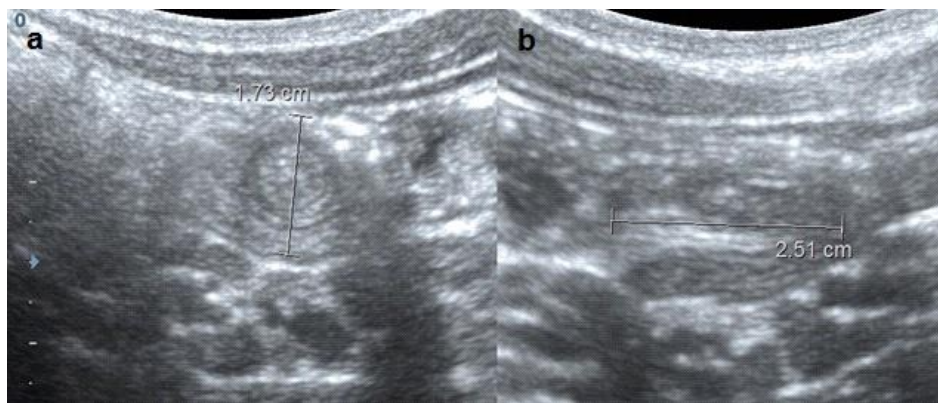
Ultrasound image of a transient enteroenteric intussusception (TEI) in the transversal (a) and the longitudinal (b) plane; the image shows a typical appearance of a TEI: small outer diameter – less than 2.5 cm (in the image of the transversal plane), short bowel segment – less than 3 cm (in the image of the longitudinal plane), and no lead point
